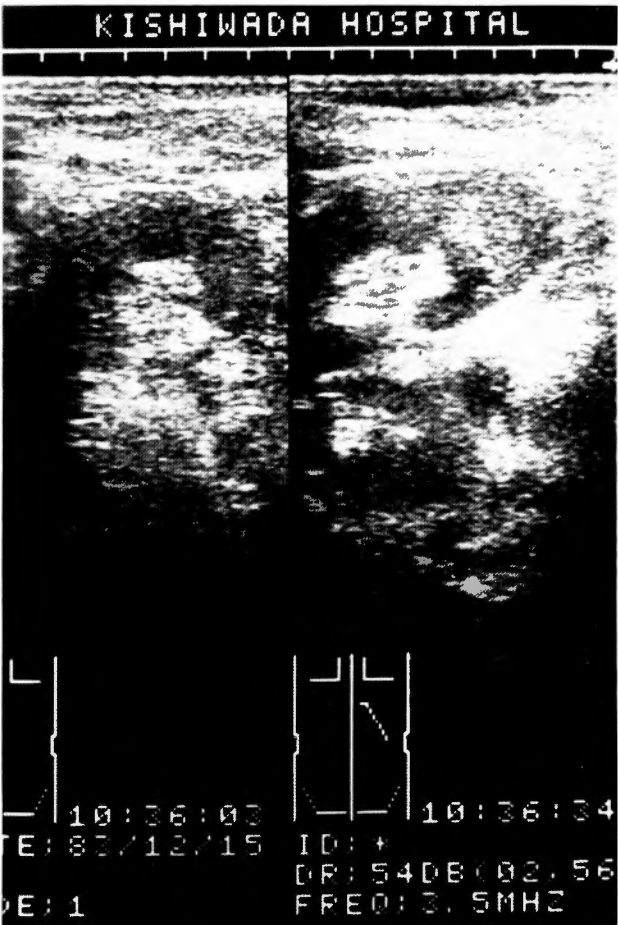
Ultrasonomogram of the abdomen showing a huge mass in the right upper abdomen.
